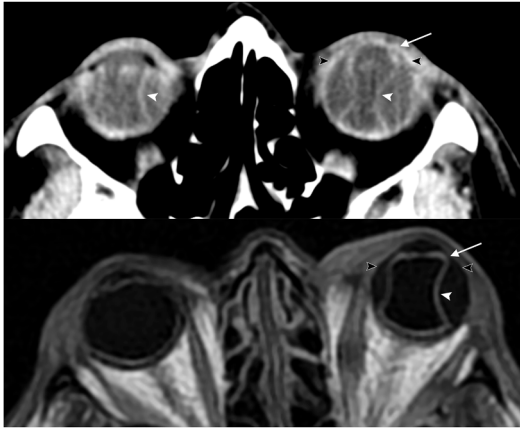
Contrast-enhanced CT orbits (*top*) and axial T2 fluid attenuated inversion recovery (FLAIR) MR sequence (*bottom*) in 2 patients show characteristic biconvex choroidal detachments, bilateral on CT, and in the left globe on MR (*white arrowheads*). The detachments extend to the ciliary body (*white arrows*) beyond the expected location of the ora serrata (*black arrowheads*).
